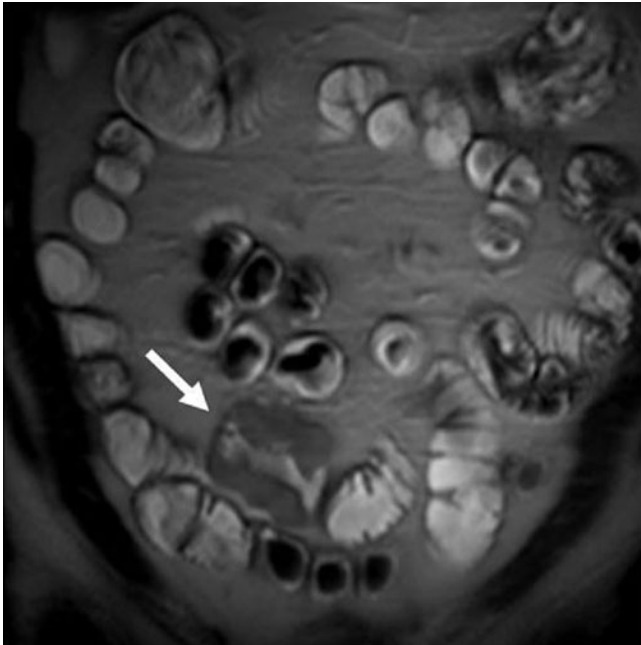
Small-bowel lymphoma: magnetic resonance (MR) enteroclysis following biphasic intraluminal contrast application (methylcellulose). T2-weighted single-shot turbo spin-echo (SSH-TSE) images in coronal plane demonstrate appropriate filling of all small-bowel loops. A short segment with marked thickening of the small-bowel wall is noted in the lower quadrants to the right of the midline (*arrow*). Intermediate signal intensity is similar to that of the bowel wall. Note that the lumen is preserved despite significant wall thickening. Also, there is no prestenotic dilatation. This appearance is characteristic of small-bowel lymphoma
